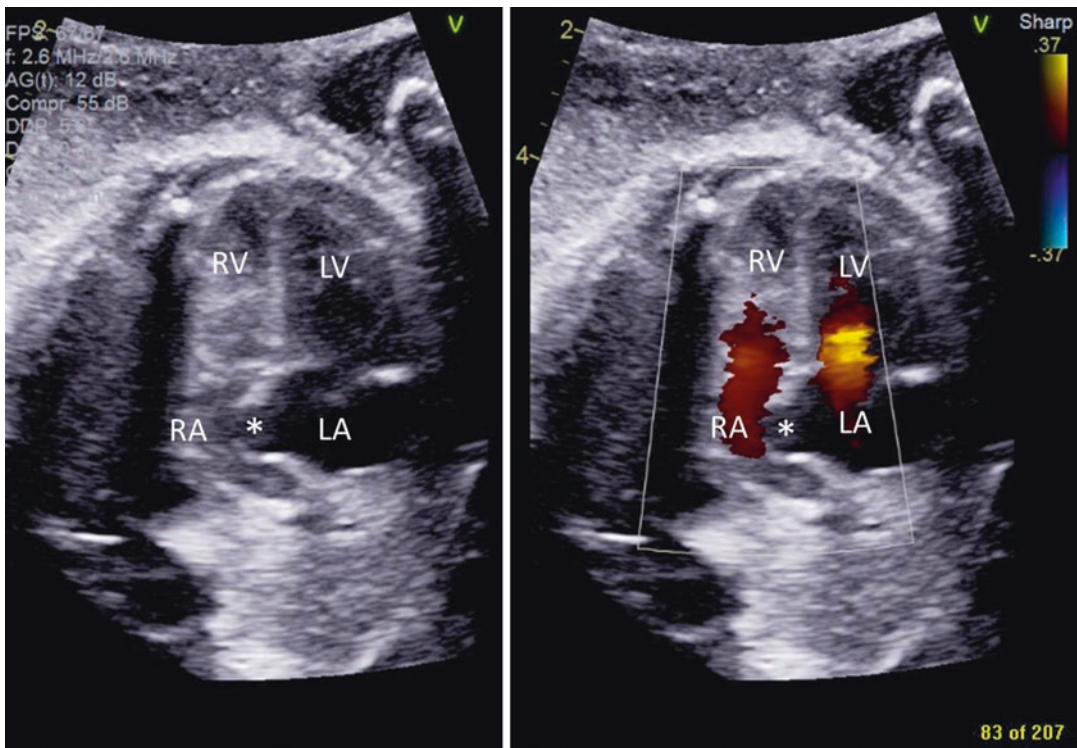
2D and color Doppler imaging of four-chamber view of a fetus with D-transposition of the great arteries and restrictive atrial septum. The atrial septum
